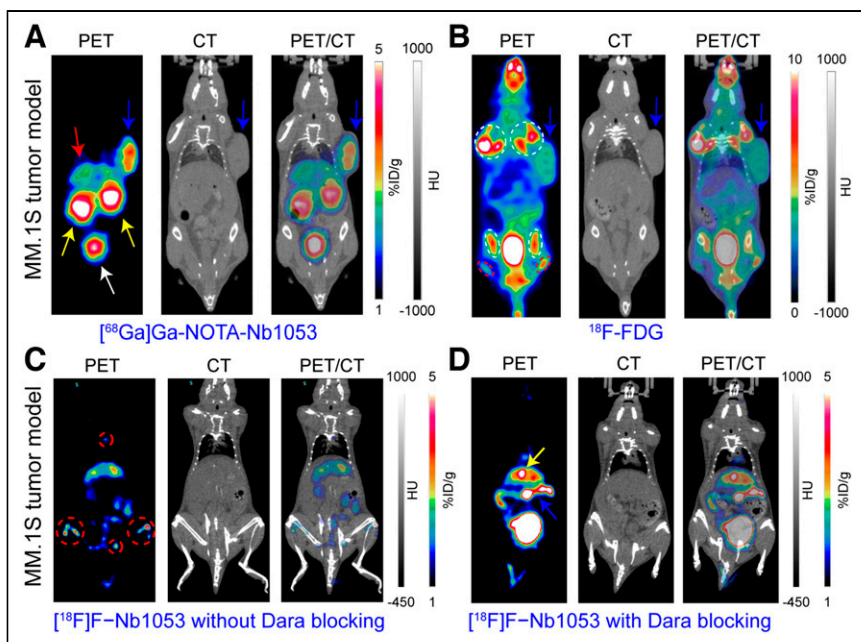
Preclinical immuno-PET imaging of multiple myelomas. (A) Immuno-PET imaging with ^{68}Ga -NOTA-Nb1053 delineated subcutaneous MM.1S tumor (blue arrows) with excellent contrast. Unbound tracer was largely excreted from urinary system (kidneys indicated by yellow arrows and bladder by white arrow), and small proportion was catabolized in liver (red arrow). (B) In comparison, PET imaging with ^{18}F -FDG visualized subcutaneous MM.1S tumor (blue arrows) with substantial uptake in normal tissues, such as bone joints (white circles) and muscles (red circles). (C) Immuno-PET imaging with ^{18}F -Nb1053 also clearly outlined involved bones (red circles). (D) In contrast, no obvious ^{18}F -Nb1053 uptake was observed in disseminated MM.1S models that were premedicated with CD38-targeting monoclonal antibody daratumumab. The gallbladder is indicated by the yellow arrow. %ID = percentage injected dose; Dara = daratumumab; HU = Hounsfield units. (Reprinted from (12,24).)
